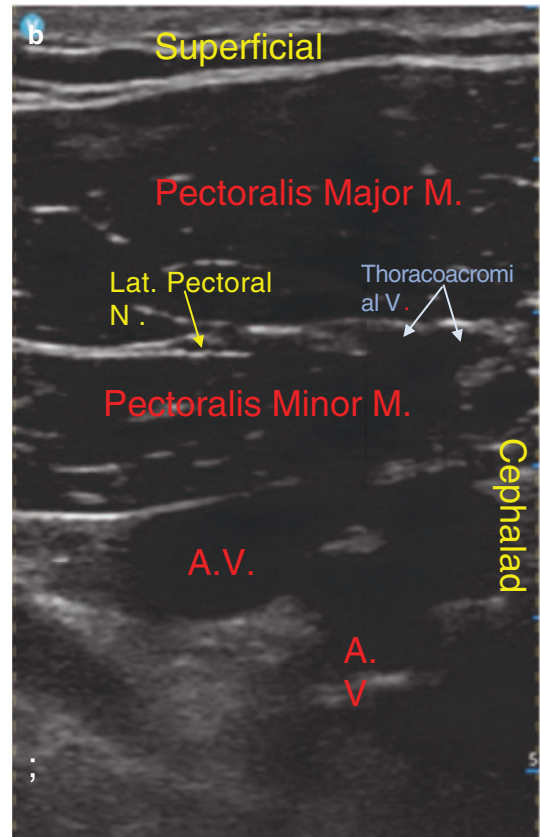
Ultrasound-guided Interpectoral Plane (IPP) Block. (a) Position of the probe for the IPP Block. Blue dot is the location of the needle approach. (b) Ultrasound image of IPP. The lateral and medial pectoral nerves along
